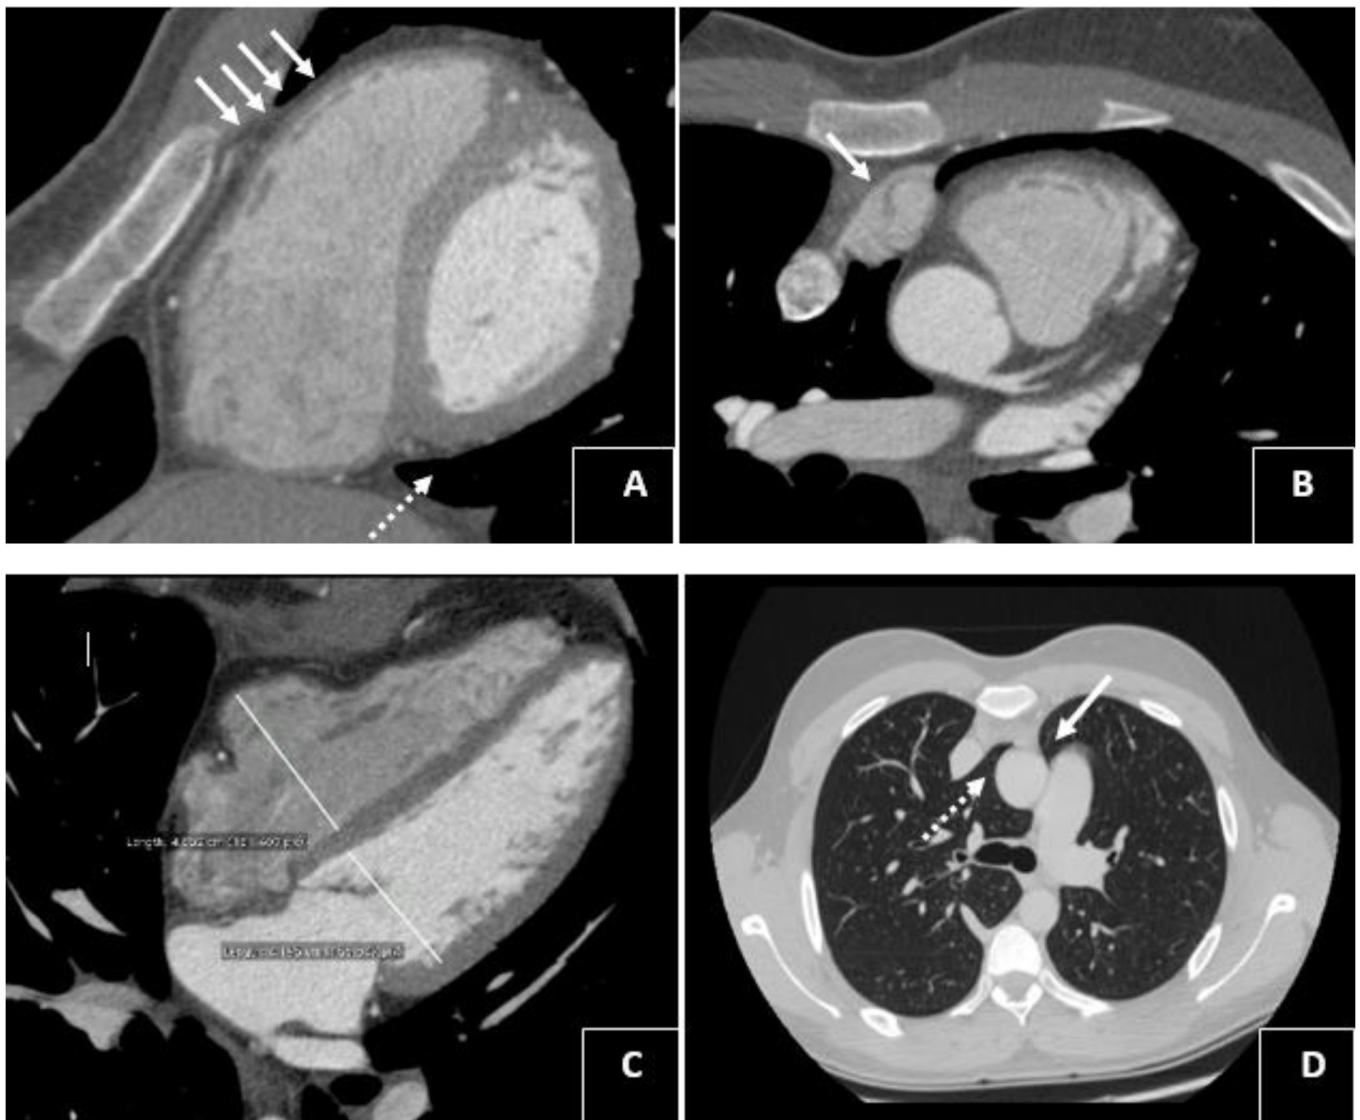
Cardiac CT demonstrating (A) the partial non-visualization of the right leaf (white arrows) and the interposition of the lung between the diaphragm and the base of the heart (dashed arrow), (B) right atrial appendage herniation (white arrow), (C) enlargement of right ventricular dimension (the right ventricular-to-left ventricular dimension ratio was 1.15), (D) interposition of the lung between the aorta and the superior vena cava (dashed arrow) and between the aorta and the pulmonary artery (white arrow).
